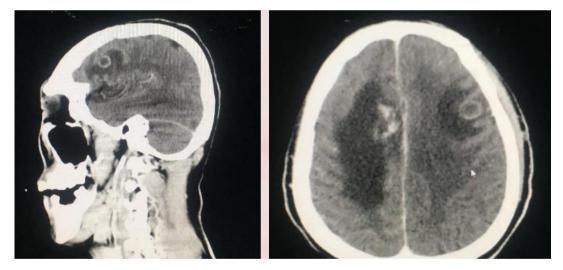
The results of the Post-Contrast Head CT-scan in the patient.
